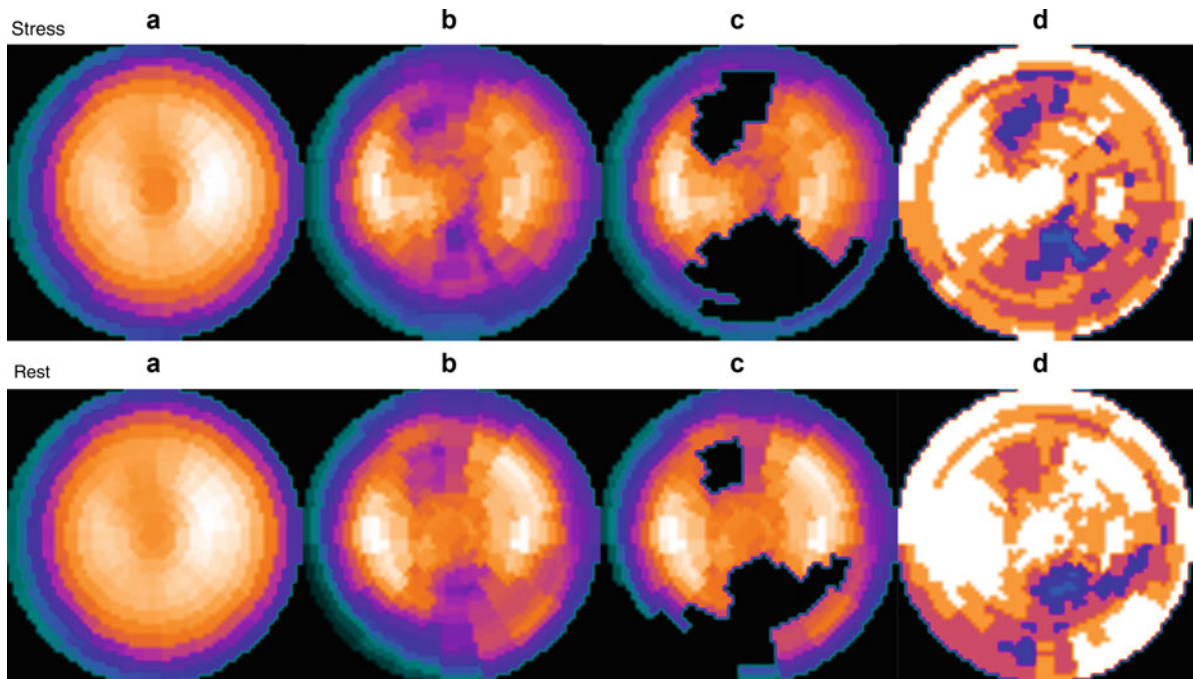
Example of SPECT database comparison (a) Stress and rest female normal file for Tc-99m 1 day sestamibi. (b) Stress and rest raw polar maps (counts extracted from the stress and rest short-axis datasets). (c) Stress and rest blackout polar maps after comparison to the normal database; blacked-out
